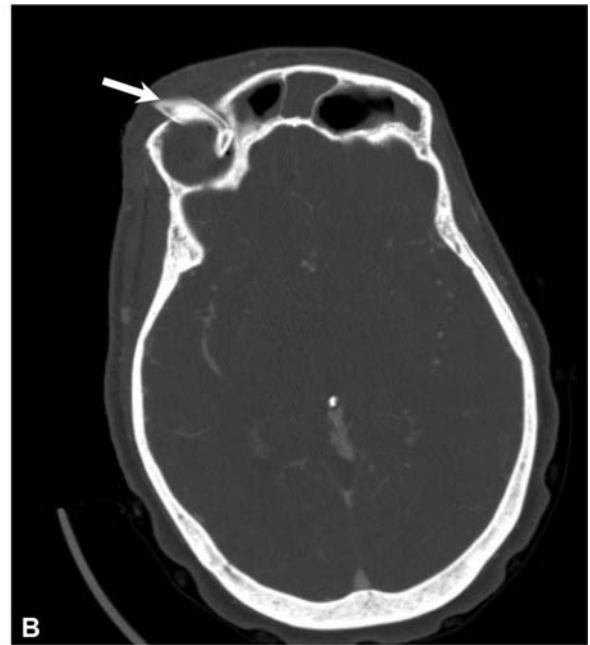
Postoperative sagittal (A) and axial (B) CT following eyebrow approach for partial orbital roof and minor inferior rim removal to access the orbital and epidural abscesses via the orbital roof. A simple rubber Penrose drain (arrow) is tunneled out of the lateral aspect of the incision. CT, computed tomography.
